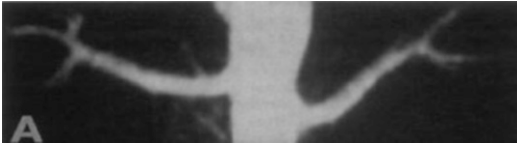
Example of time-of-flight MRA of the renal arteries in a healthy volunteer. (Reprinted from King BF et al. *Semin Ultrasound CT MR* 1996;17(4):398–403 [69] with permission by Elsevier)
